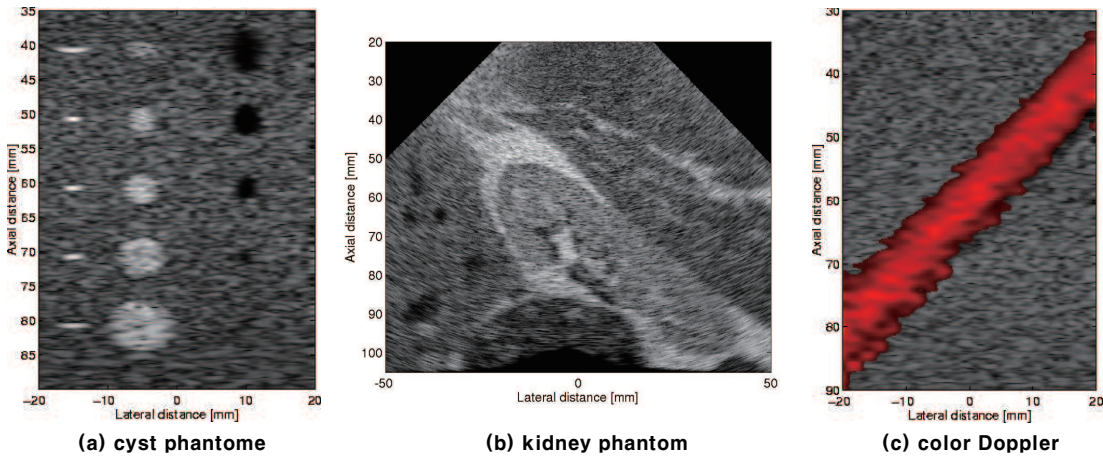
Examples of ultrasound synthetic images generated by using Field II.
